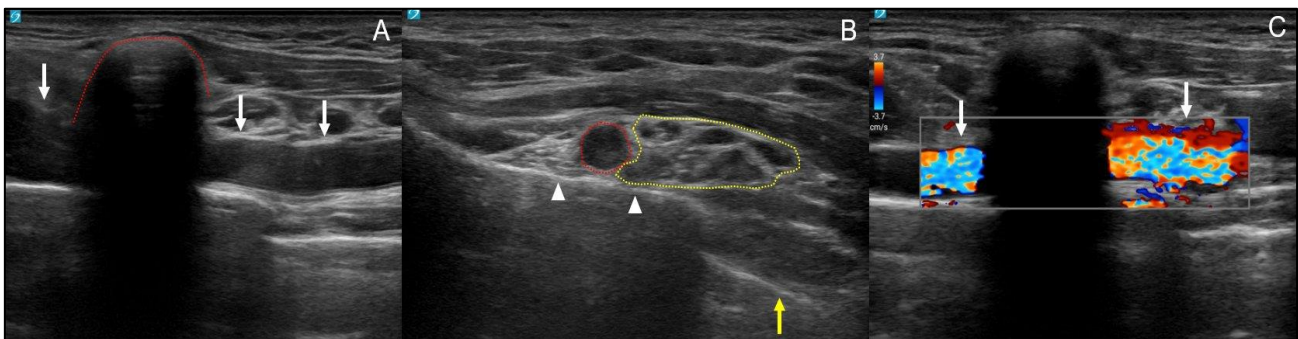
Ultrasonographic evaluation in the neutral arm position.
